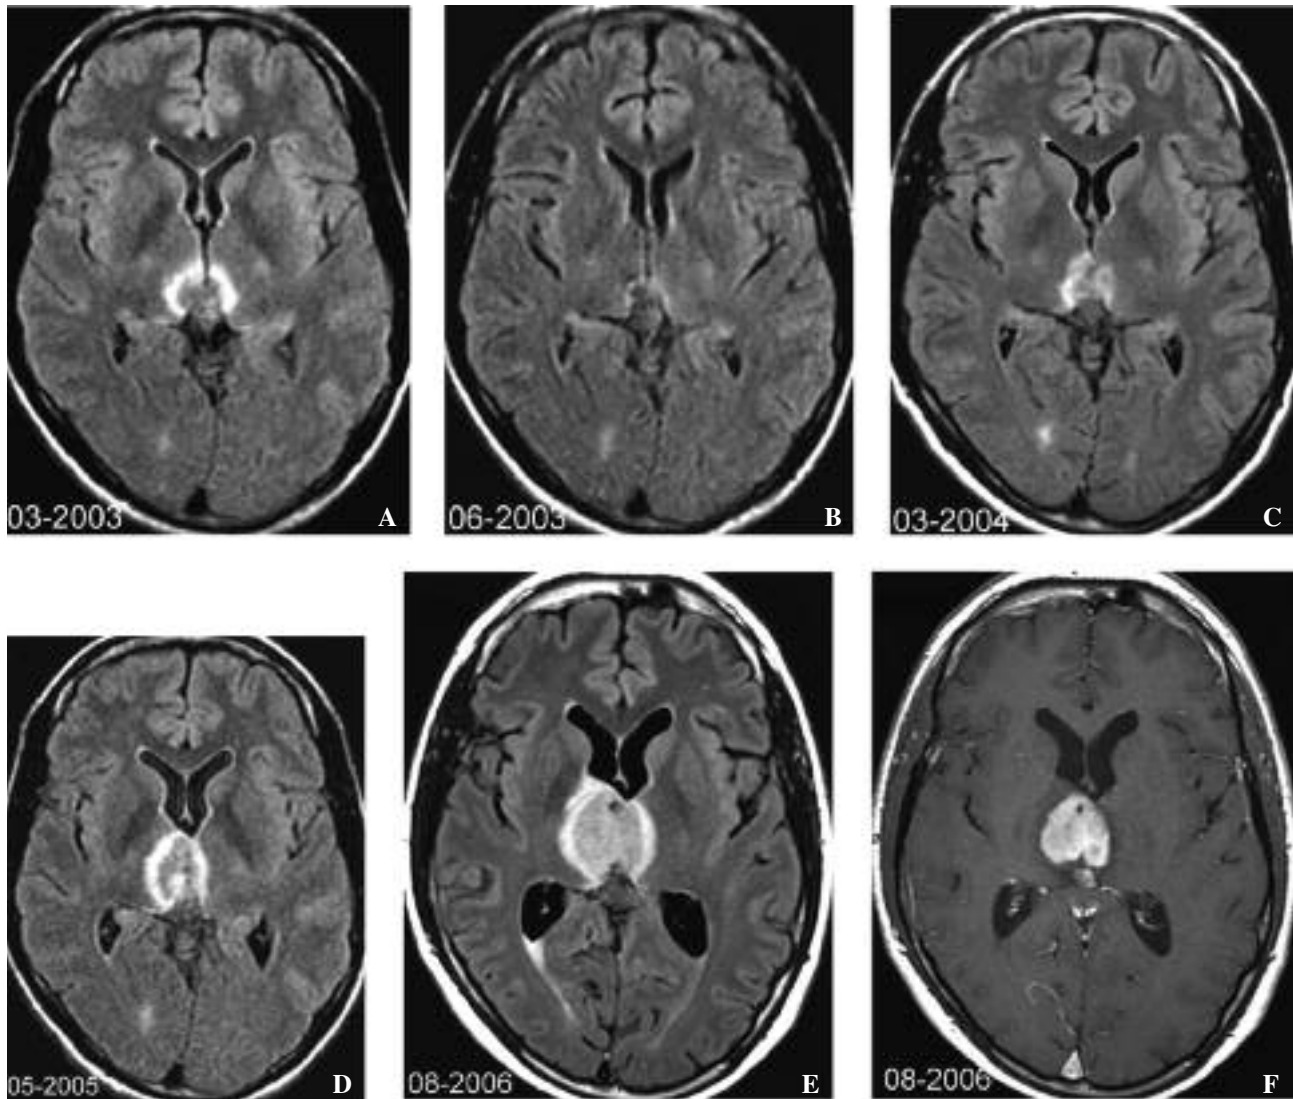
Pre-treatment brain MR images of patient #1.
